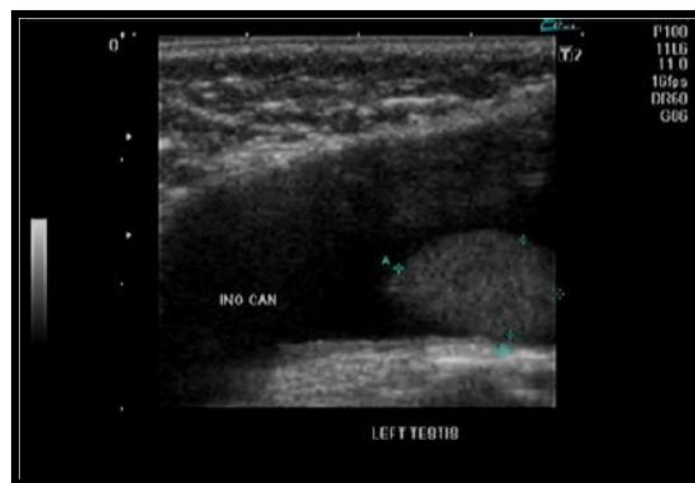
shows, the left inguinal testis (see ultrasound images of left inguinal testis below). (Pillai and Besner, 1998).
